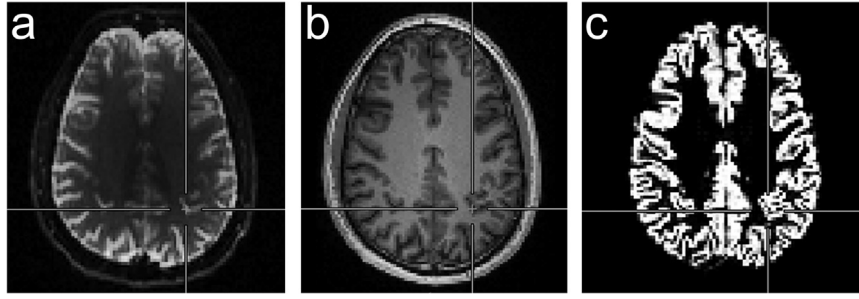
Representative example of the co-registration of the T1-weighted anatomical volume (b) into the b0-volume (a). For this volunteer (male, 31 years old) the co-registered probability tissue map of gray matter (c) is reported as well. Cross lines are shown to help comparison between images.
